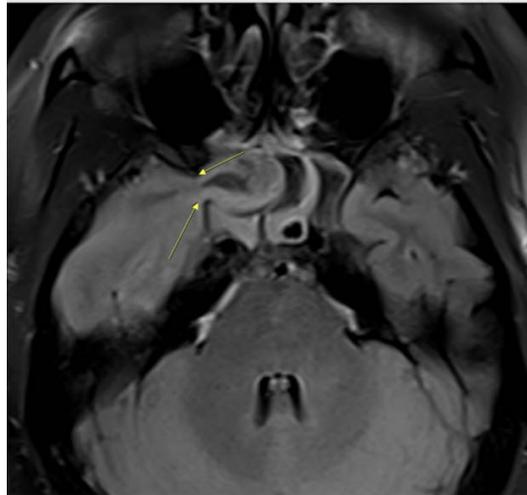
Axial FLAIR with arrows indicating the defect at the lateral wall of the right sphenoid sinus.
